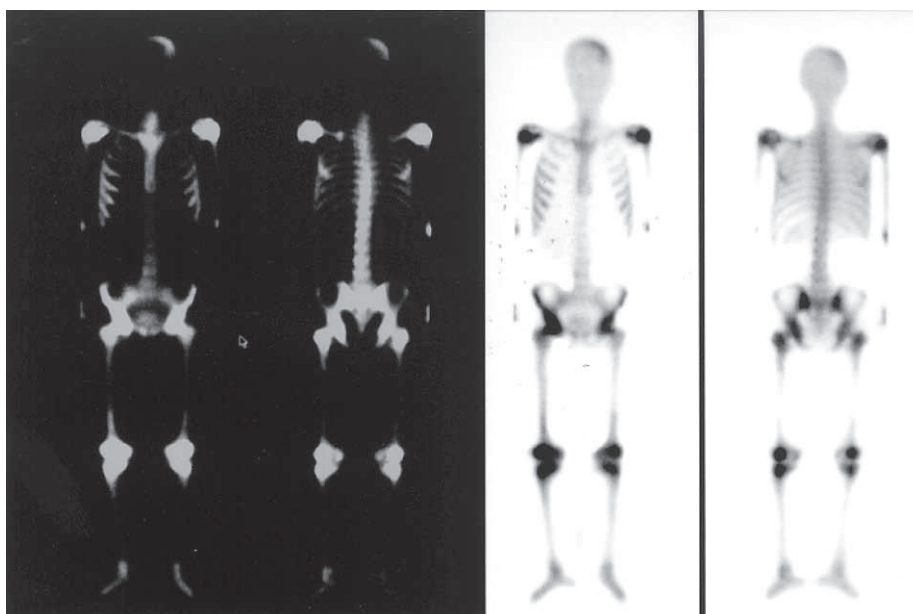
Tc-99m MDP bone scintigraphy showed increasing osteoblastic activity in the left frontal and parietal bones and in shoulders, knee and ankle joints, and in both metatarsal bones.
